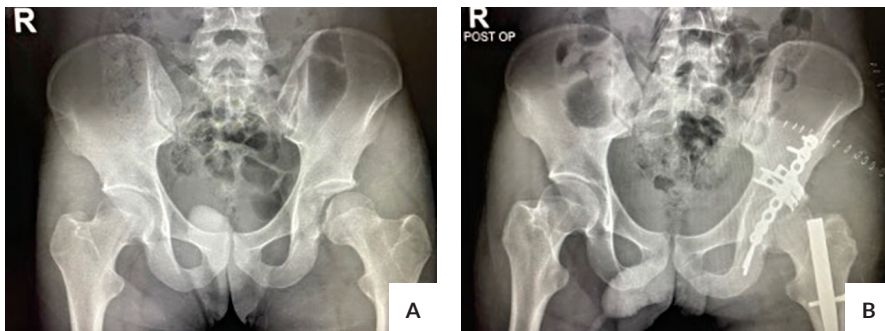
Radiographs from Patient 5 – Male, 24-year-old, car accident. (A) Preoperative, (B) Immediate post-operative.
